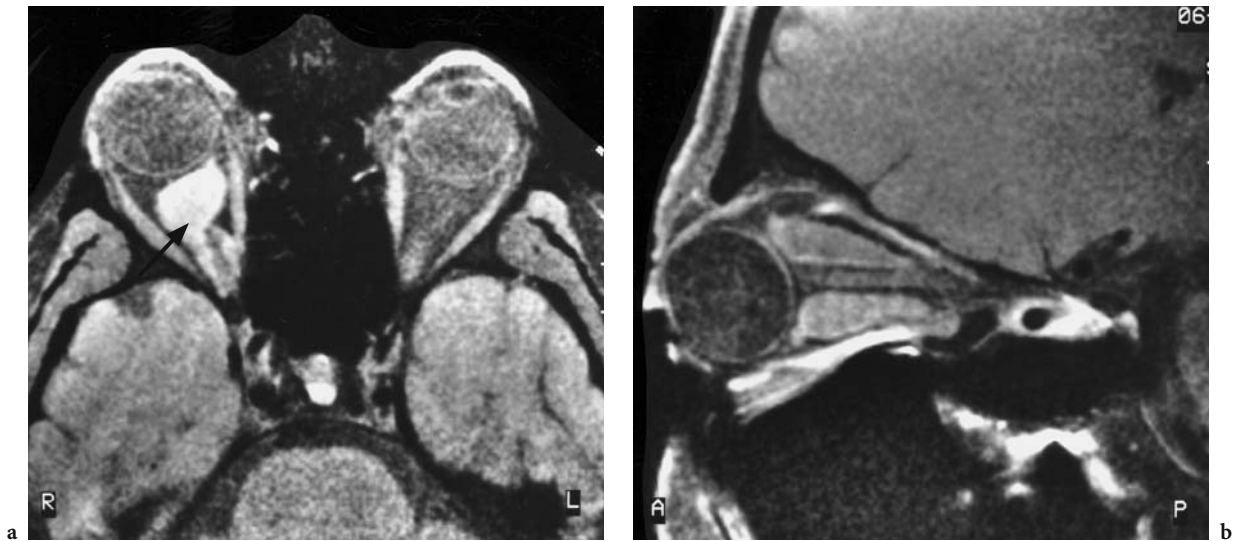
A 42-year-old man with recurrent exophthalmos. Diagnosis: orbital venous anomaly. Contrast-enhanced MRI: a Axial view with an intraconal, lobulated but sharply defined, hyperintense formation with extension into the apex of the orbit, where the optic nerve demarcates as a hypointense structure (*arrow*). b Parasagittal view demonstrating the infra- and supraoptic sections of the varices as well as expansion towards the orbital apex and optic canal. (With permission of MÜLLER-FÖRELL and LIEB 1995b)
